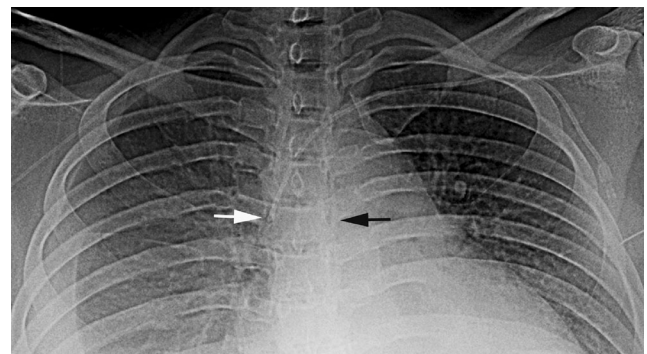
Case 3, a 19-year-old woman with renal sarcoma. Anteroposterior chest radiograph shows a normally placed left subclavian venous catheter (*white arrow*) and an arterially placed catheter inserted via a right subclavian approach (*black arrow*). Note course of arterial catheter to left of the thoracic spine, exaggerated inter-catheter crossover distance, and moderate right pleural effusion
